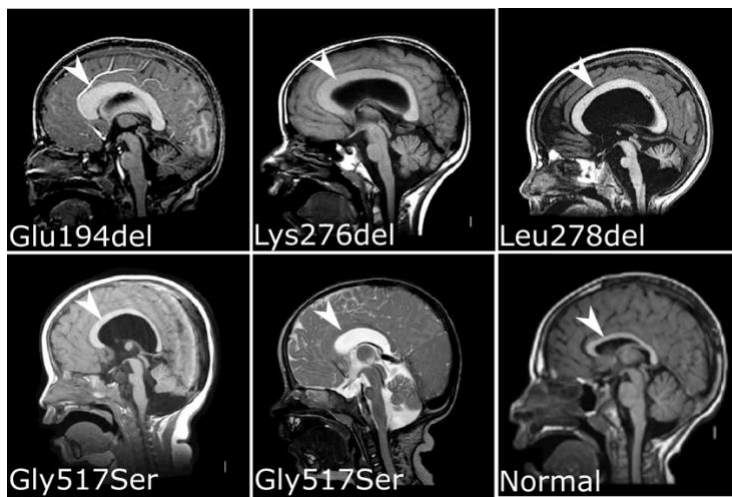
Patients with MAST1 mutations. Magnetic resonance images of five MCC-CH-CM patients and a healthy patient in the midline sagittal plane. The corpus callosum is indicated (arrowheads). The specific MAST1 mutations are shown. Adapted from: Tripathy et al. 2018.
